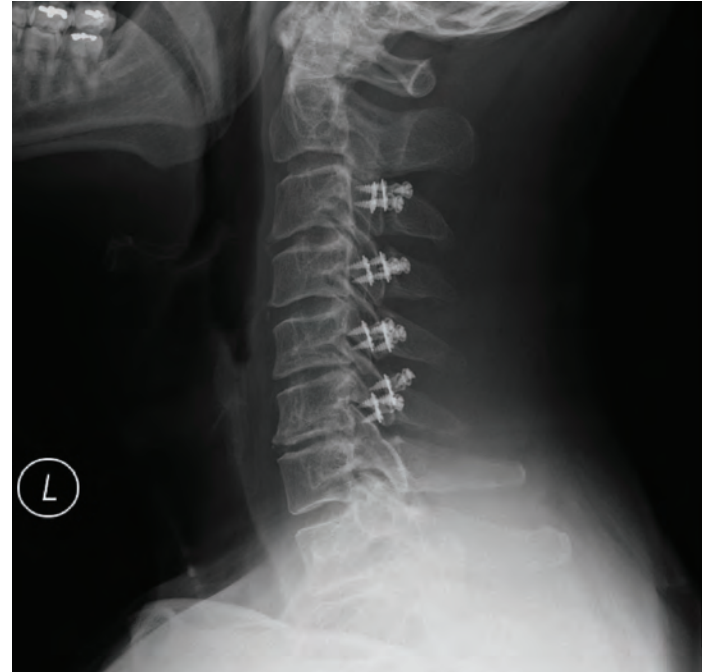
Lateral view of the post-operative x-ray shows the small titanium plates placed in Sean's neck during the laminoplasty procedure.
